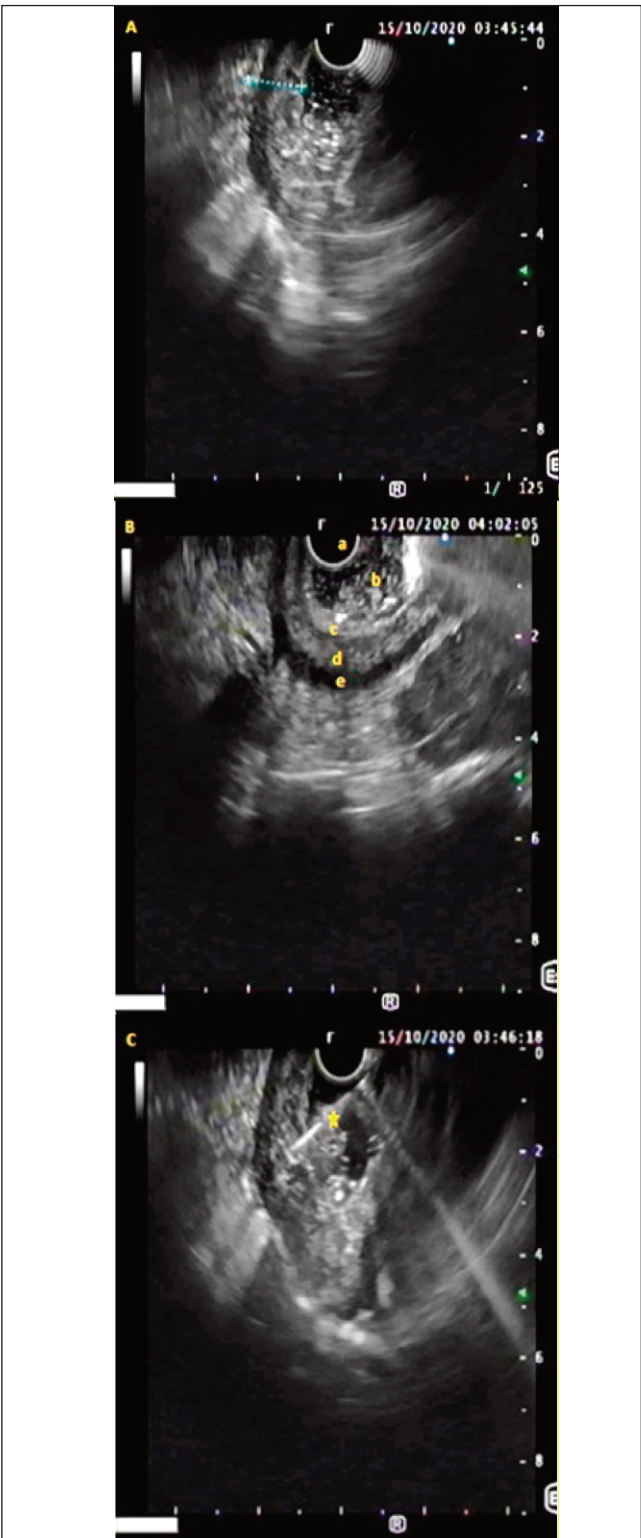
(A) Endoscopic ultrasound (EUS) showing thickened gastric wall (12.8mm). (B) EUS showing probe (a), water filled in stomach (b), mucosa (c), submucosa (d) and muscularis propria (e). (C) Fine needle aspiration is being done with 22G EZ Shot 2 Olympus Medical needle (*).
